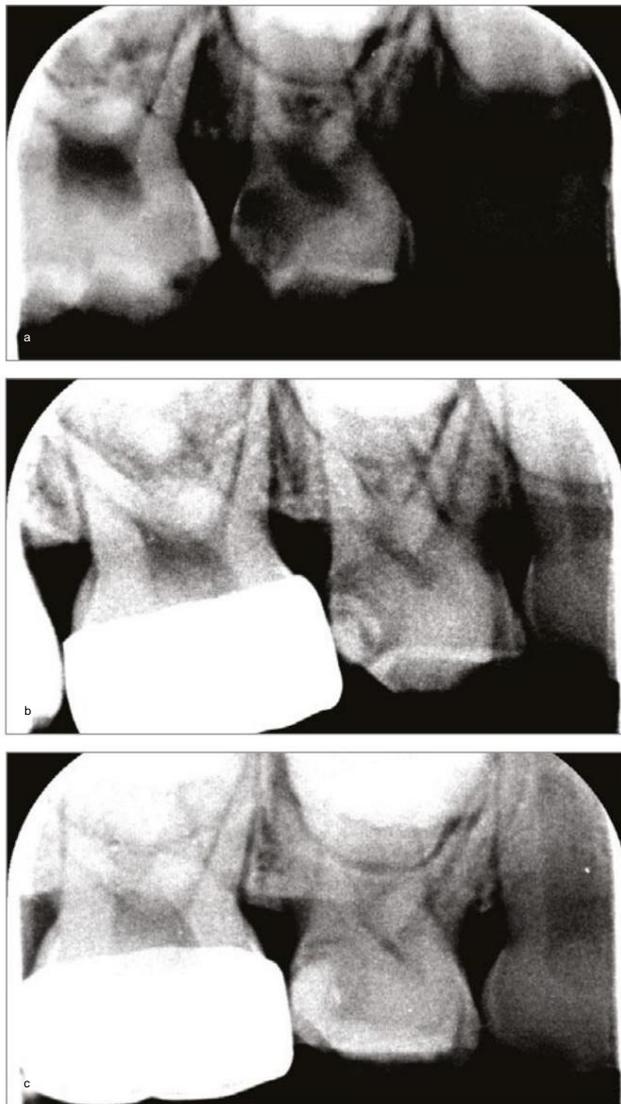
In a child with deep active lesions in 55/54 SDF was applied in January and June of 2018; on tooth 55 a Hall crown was placed; crown cement formed a protective layer for the cavity in tooth 54 (a). SDF and a layer of high-viscosity glass ionomer cement was applied on 54 in July 2018 (b). November 2020: the pulp of 54 has remained vital after this minimally invasive treatment and a layer of tertiary dentin is visible on the x-ray (c, d)
